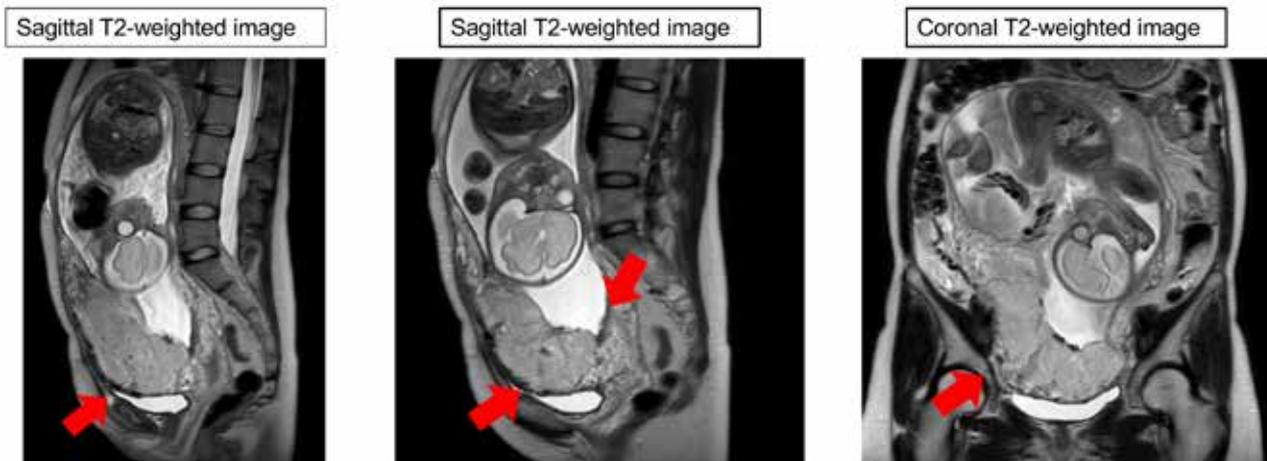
Magnetic resonance imaging (MRI) examination at 29 weeks and 1 d of gestation MRI findings at 29 weeks and 1 d of gestation. The arrow indicates the cesarean scar site. Although irregularities of the serosal surface and obscuration of the boundary with the bladder were observed, no obvious myometrial dehiscence was noted.
